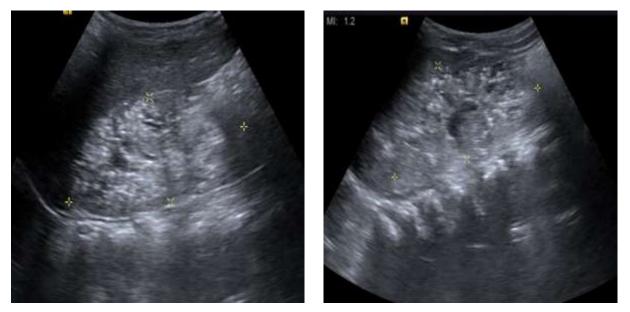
Ultrasound images showing bilateral echogenic kidneys with multiple tiny discrete calcifications.
